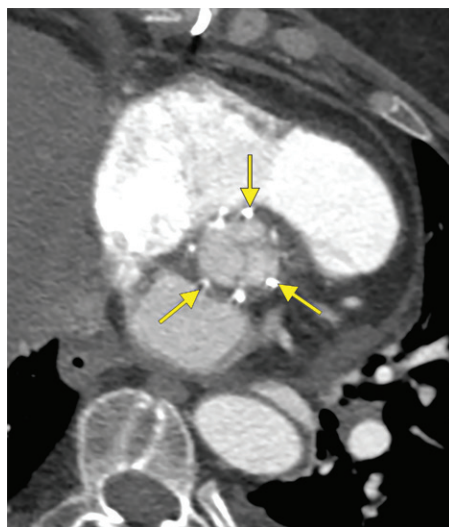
Automatic suture fasteners in a 65-year-old man after valve-sparing ascending aorta repair. Axial CT image shows metallic hyperattenuating structures (arrows) about the aortic annulus. These are Cor-Knot (LSI Solutions) automatic suture fasteners, which are used as a faster alternative to hand tying.
